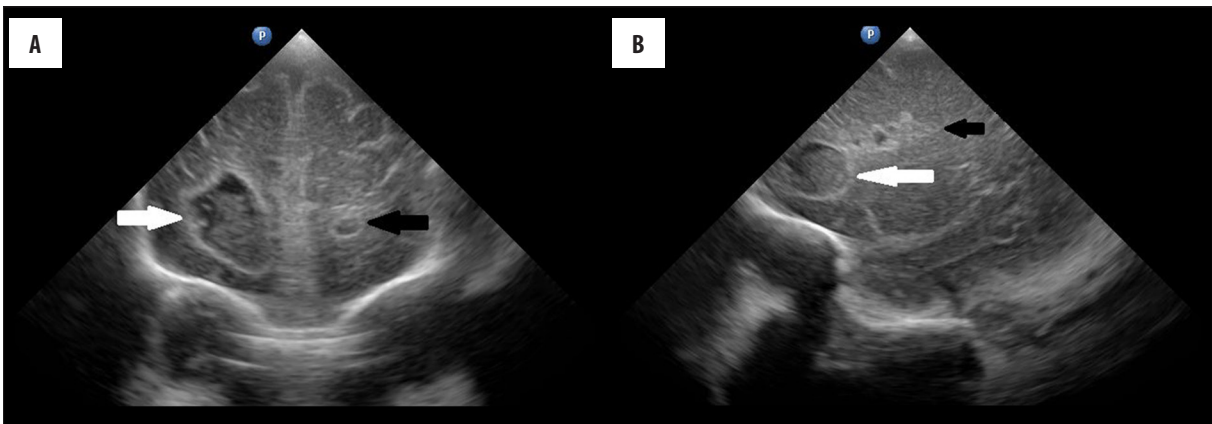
Cranial ultrasonography of the patient on the 46th day of life. (A) Frontal plane image showing multiple brain abscesses in both frontal lobes. A large abscess is located in the right frontal lobe (white arrow) and a smaller one in the left frontal lobe (black arrow). (B) Sagittal plane image showing a brain abscess located in the left frontal lobe (white arrow), and changes in that area (black arrow).
